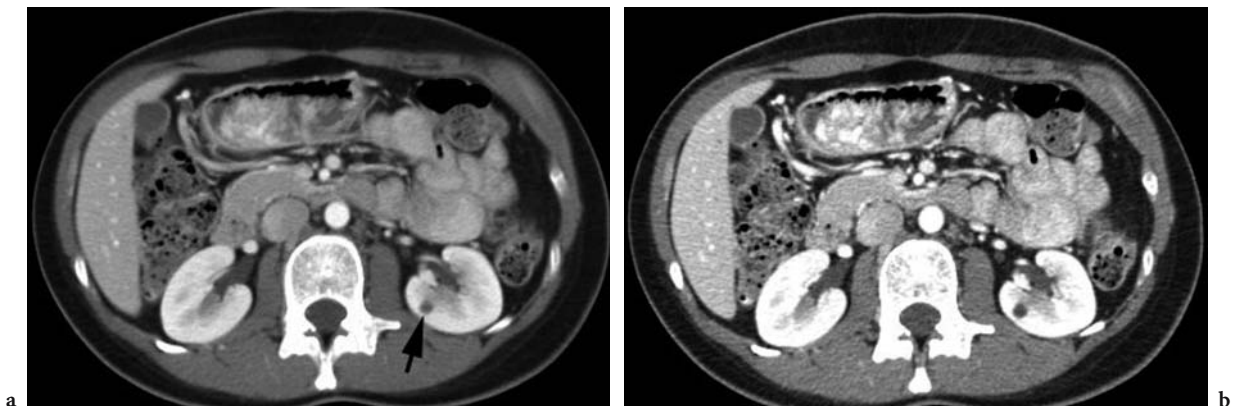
Simple cyst in a 42-year-old woman with breast cancer in whom an overlapping thin-section reconstruction on 16-slice MDCT was performed to evaluate an indeterminate small renal mass. a Axial contrast-enhanced CT scan shows 6 mm hypodensity in the left kidney (*arrow*) which measures 48 HU, not consistent with a simple cyst. b Axial 1.25-mm reconstructed CT image with repeat measurement of 6 HU confirms that the lesion is a cyst.
